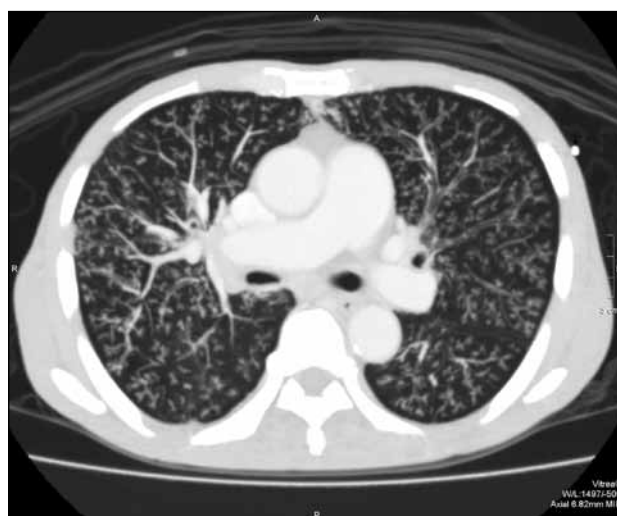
An adult male patient with panbronchiolitis: an axial post-contrast computed tomographic scan of thorax in a lung window and maximal intensity projection showing diffuse tree-in-bud opacities involving all lobes in both lungs.
